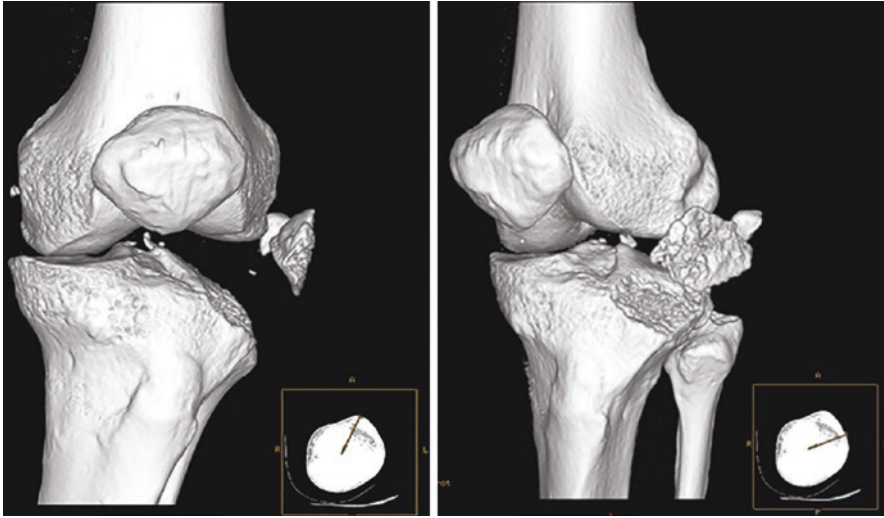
Exceptionally large and rare Segond's fracture on CT and 3D CT
